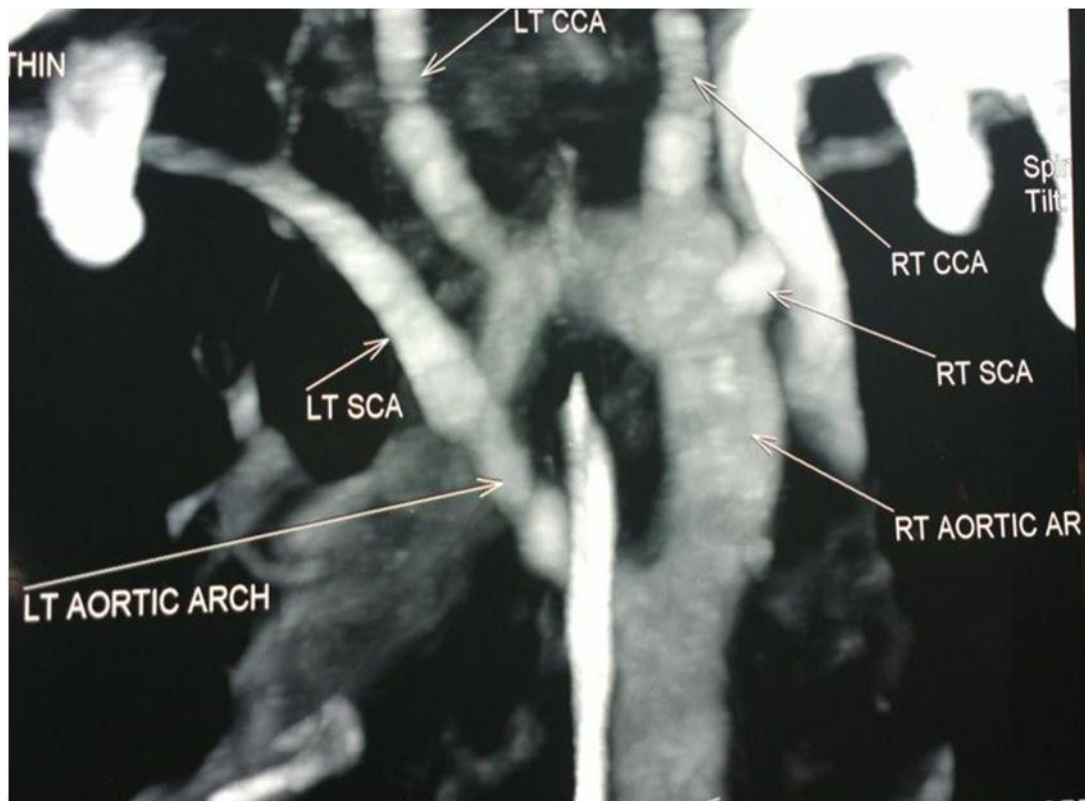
Cardiac CT showing double aortic arch
